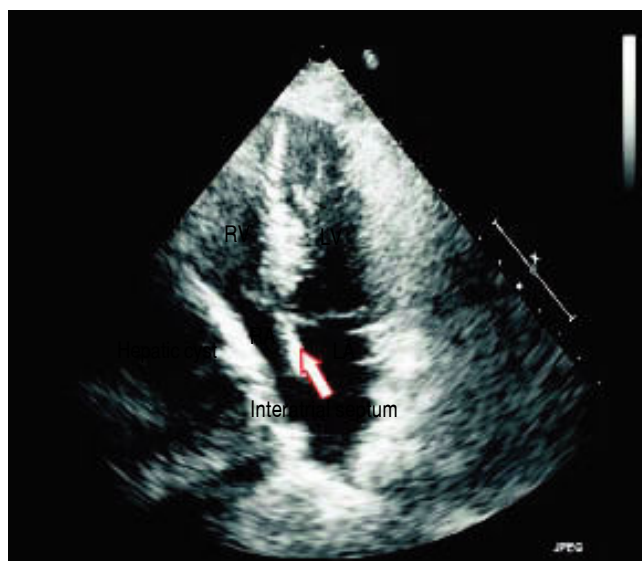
Echocardiogram on presentation showing right heart compression.
